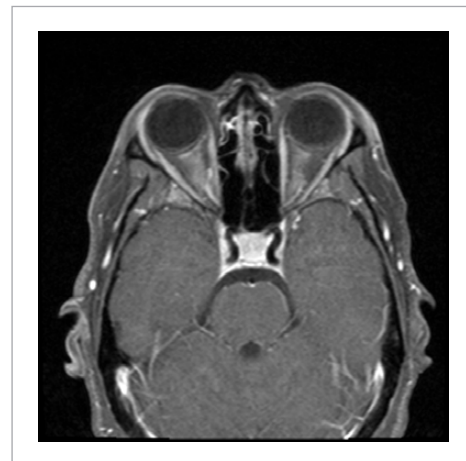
MRI of the orbits shows bilateral longitudinal enhancement of the optic nerves with perineural enhancement that is classic for MOGAD optic neuritis.
